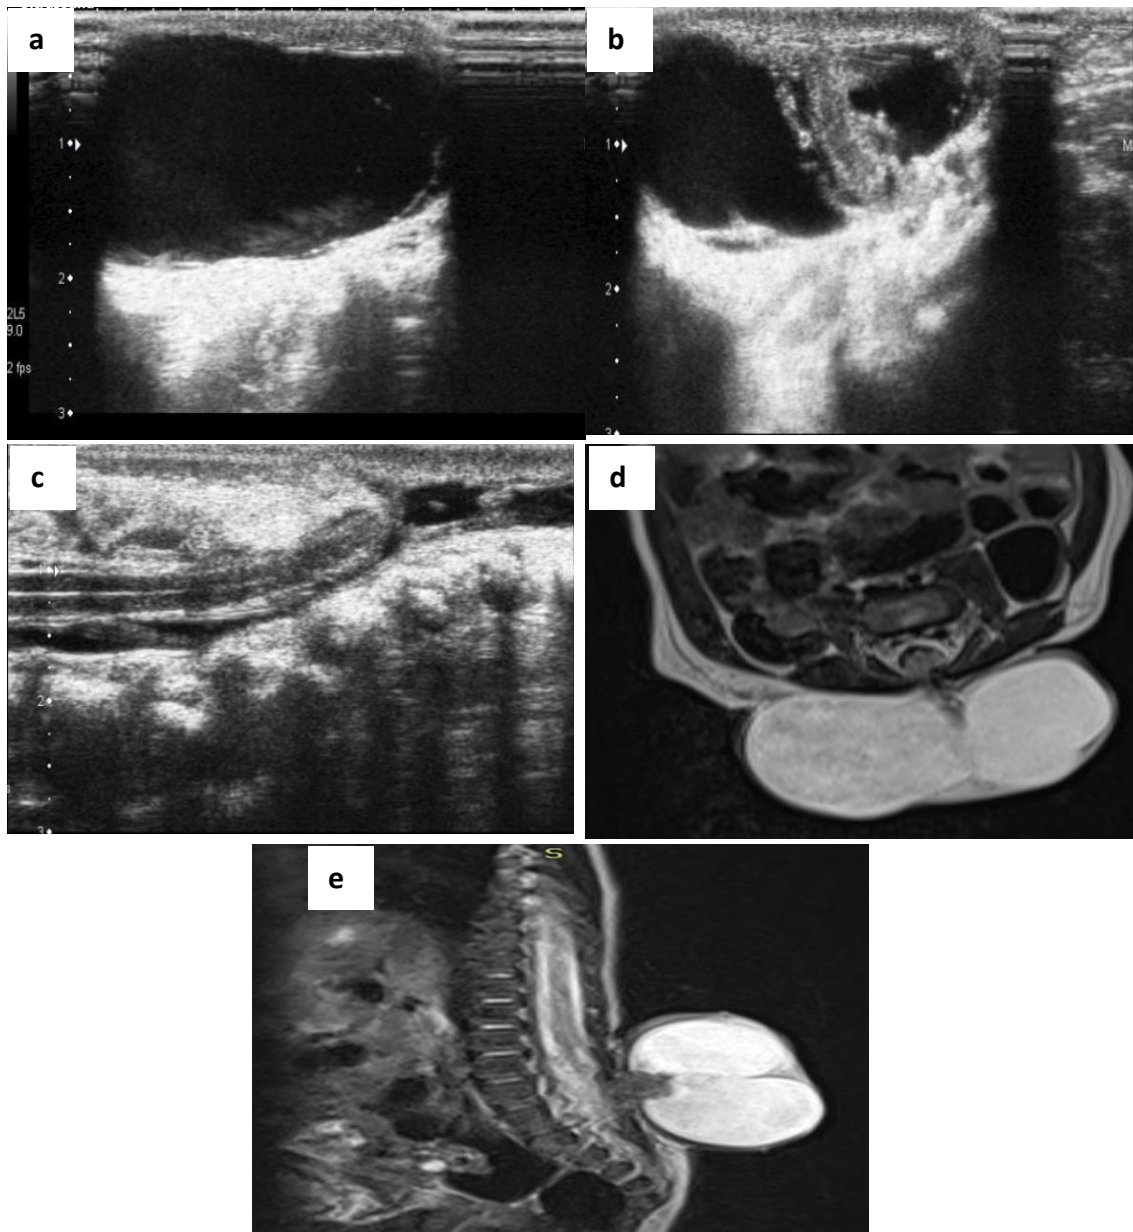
Case 2: preterm 30 day female with lower back swelling and paraplegia. A) Transverse USG showed large lumbar cystic lesion contain CSF. B) Transverse USG showed that the previous mention cyst contains spinal cord, some nerve roots and neural placode passing through lumbar defect. (myelomeningocele). C) Longitudinal USG shows a posterior arch defect at lumbar region through which the cord passing to the cystic lesion. (tethered cord). D) Axial T2W MRI shows large cystic lesion protruded through posterior arch defect at L4 and L5 contains spinal cord, neural placode, nerve roots and CSF. (myelomeningocele). E) Sagittal T2W MRI show the same of axial cuts. Final diagnosis in both MRI and USG was myelomeningocele with tethered cord Agreement frequency between the two modalities used =100%.
